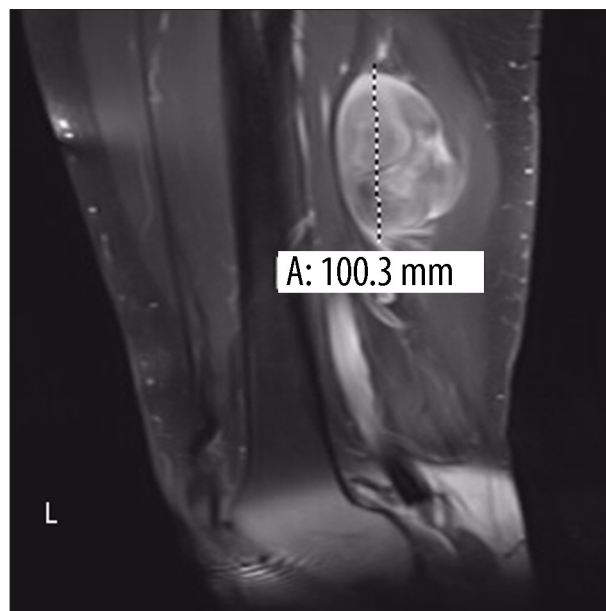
MRI of left thigh: Incidental mass which was highly suspicious of another sarcoma 10×6×4.6 cm in the posterior aspect of the mid-thigh.
